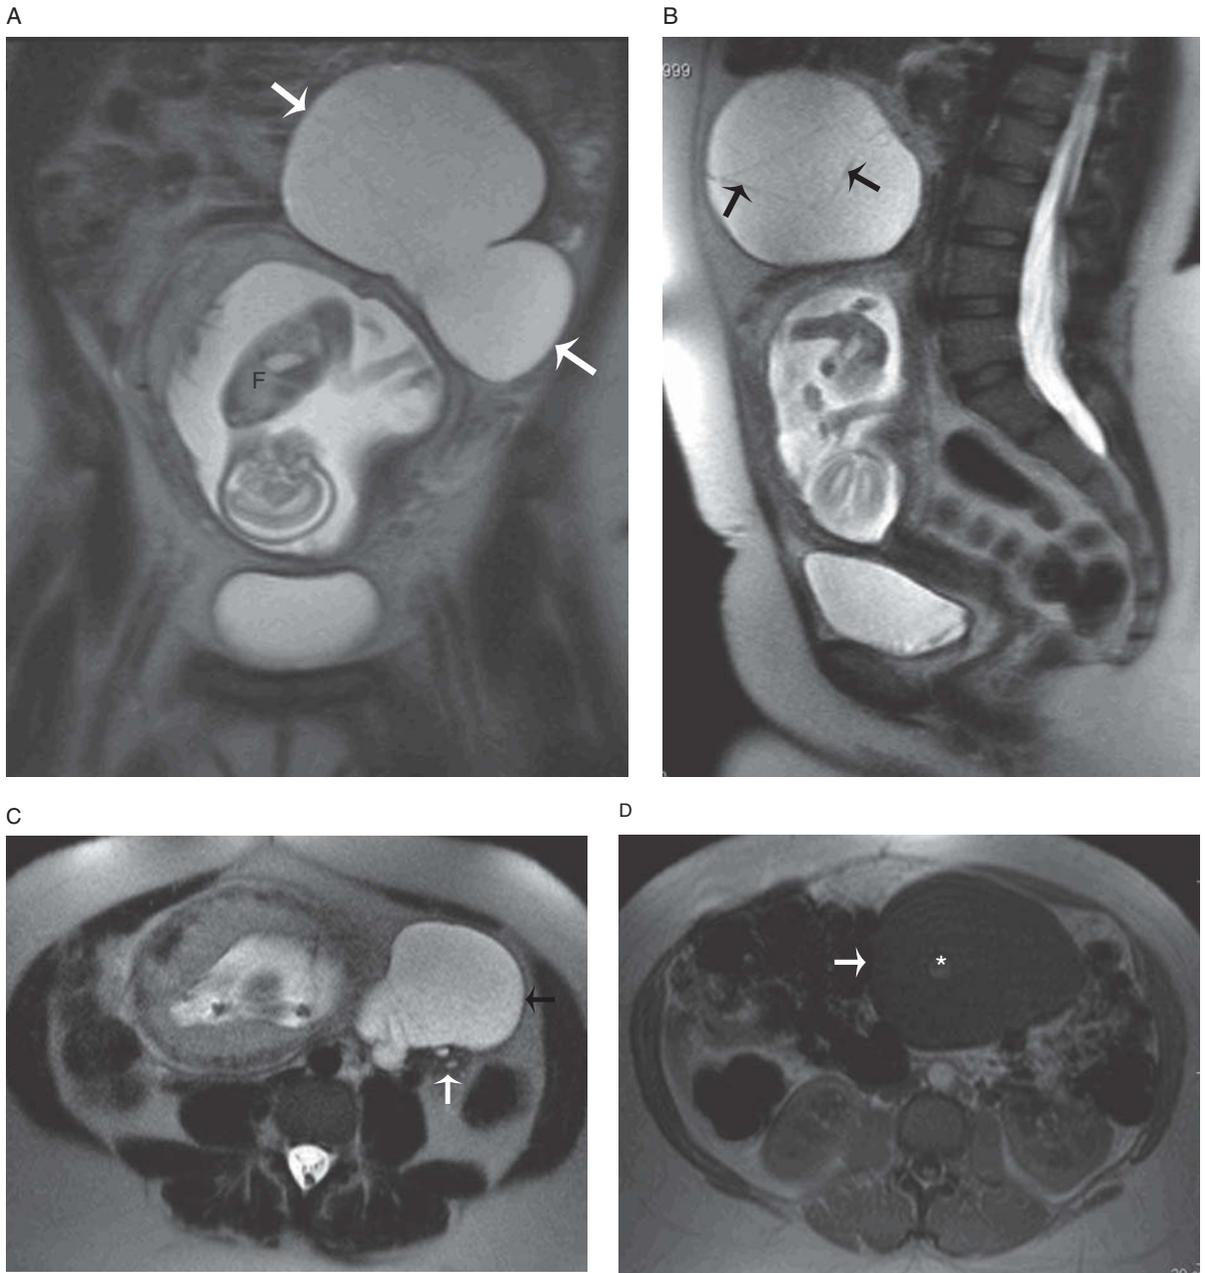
Mucinous cystadenoma in a 26-year-old pregnant female. Coronal T2-weighted image (A) demonstrates a 12 cm, high T2 signal intensity cystic lesion (arrows) in the left adnexa, extending superior to the gravid uterus. Note fetus (F). Sagittal T2-weighted image (B) further demonstrates that there are several thin internal septations in the cystic lesion (arrows). Axial T2-weighted image (C) confirms that this lesion (black arrow) arises from the left ovary; note normal ovarian tissue with a few subcentimeter follicles (white arrow) along the posterior aspect of the cyst. Axial T1-weighted image (D) without fat saturation reveals uniform intermediate T1 signal intensity in the cyst (arrow). Note aortic pulsation artifact in the cyst (*).
